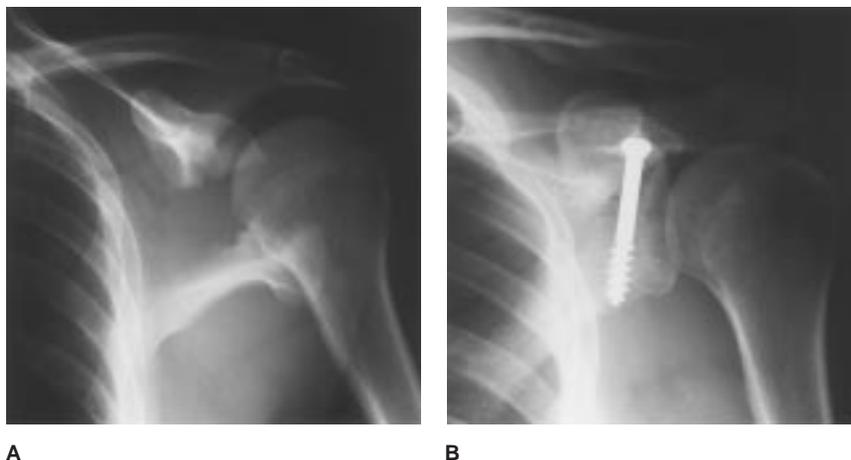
Radiographs of a patient who sustained a type IV fracture of the glenoid cavity. A, Preoperative AP radiograph shows severe separation of the superior and inferior segments of the glenoid fossa and scapular body. B, Postoperative AP radiograph shows anatomic reduction and stabilization of the superior and inferior segments of the glenoid fossa and scapular body with restoration of articular congruity.
